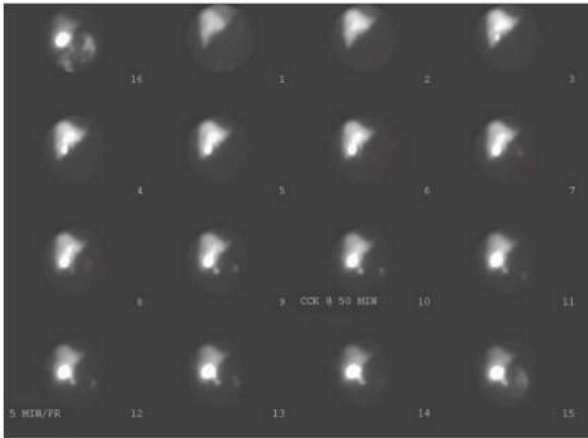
• HIDA cholescintigraphy scan. Filling of the gallbladder during a HIDA scan, as in this study, essentially eliminates the diagnosis of cholecystitis.
